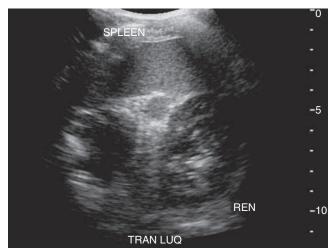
Transverse sonogram of the left upper quadrant.
